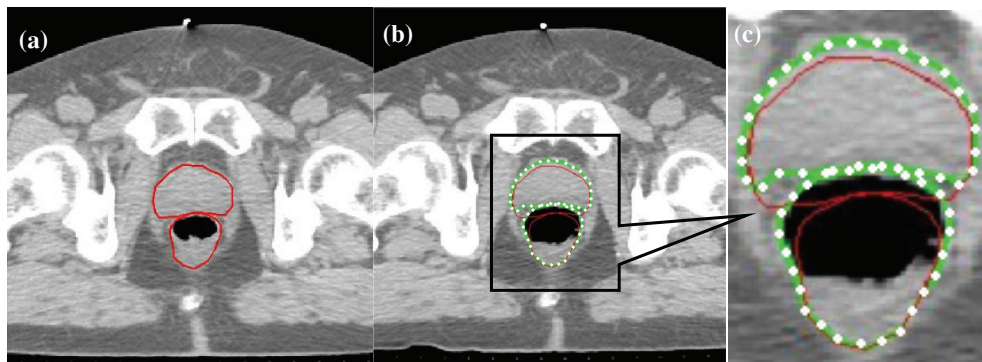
(Left): First daily CT with physician-drawn contours for prostate and rectum. (Middle): Second daily CT with first daily CT contours overlaid (red) and deformed contours by deformable registration (green with white dots). (Right): Centre part of middle image enlarged to show correction of deformed contours.
